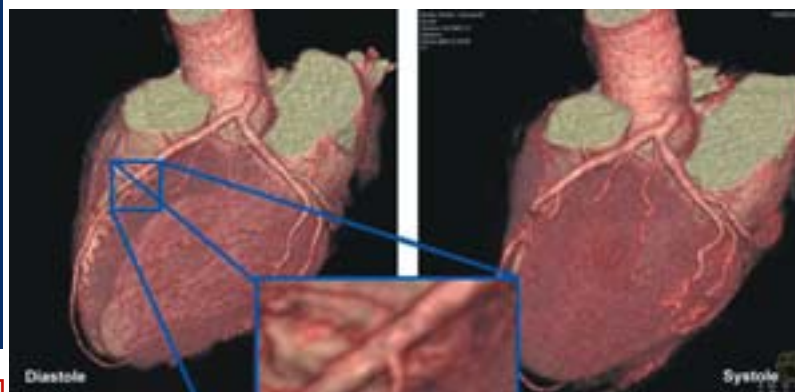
100% reliability in coronary CT angiography with dual-source CT is now possible (Courtesy of S Achenbach MD, Erlangen)
